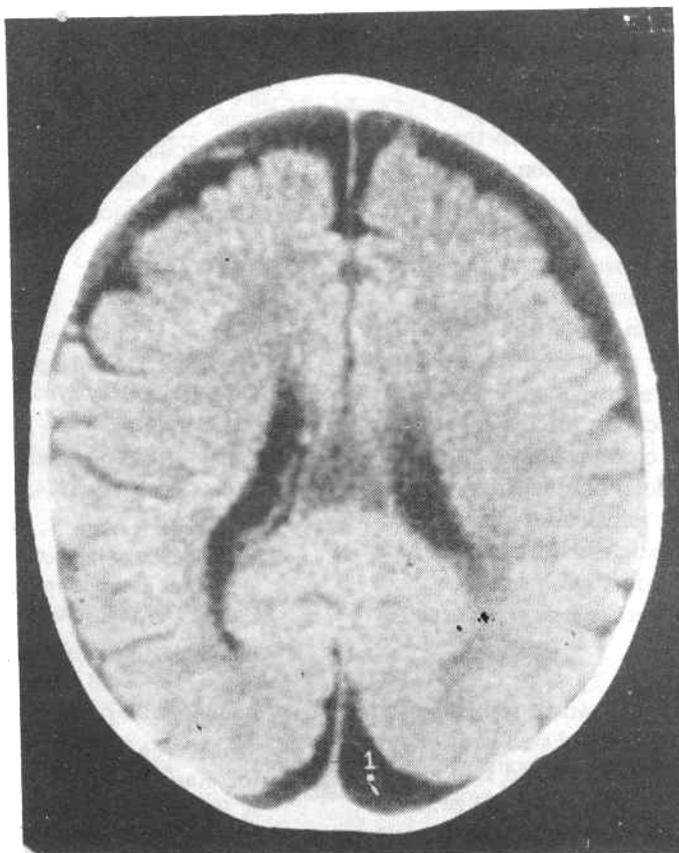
MRI showing chronic sub-dural hematoma extending into posterior interhemispheric region.
